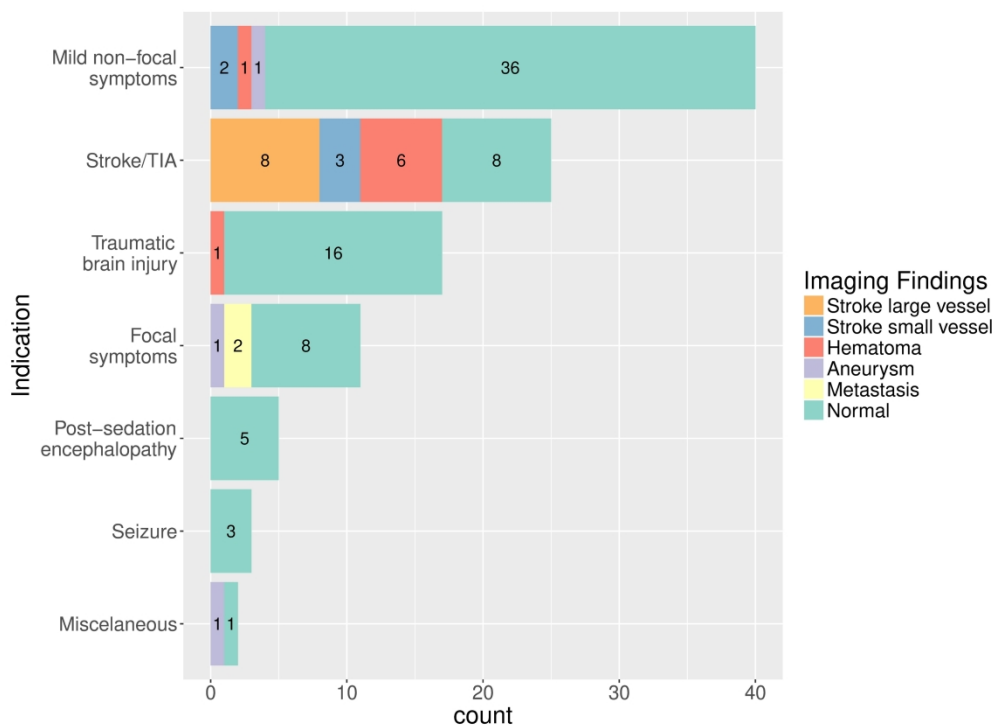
Summary of results, including all neuroimaging patients (MRI/CT). Reason for neuroimaging on the y-axis. Neuroimaging findings color-coded in legend. Notes: Mild non-focal neural symptoms refers to any mild state of altered consciousness, mild transient dysarthria, mild transient gait abnormality, or headache; lacunar or small distal cortical infarctions not susceptible to thrombectomy were considered "small-vessel."
